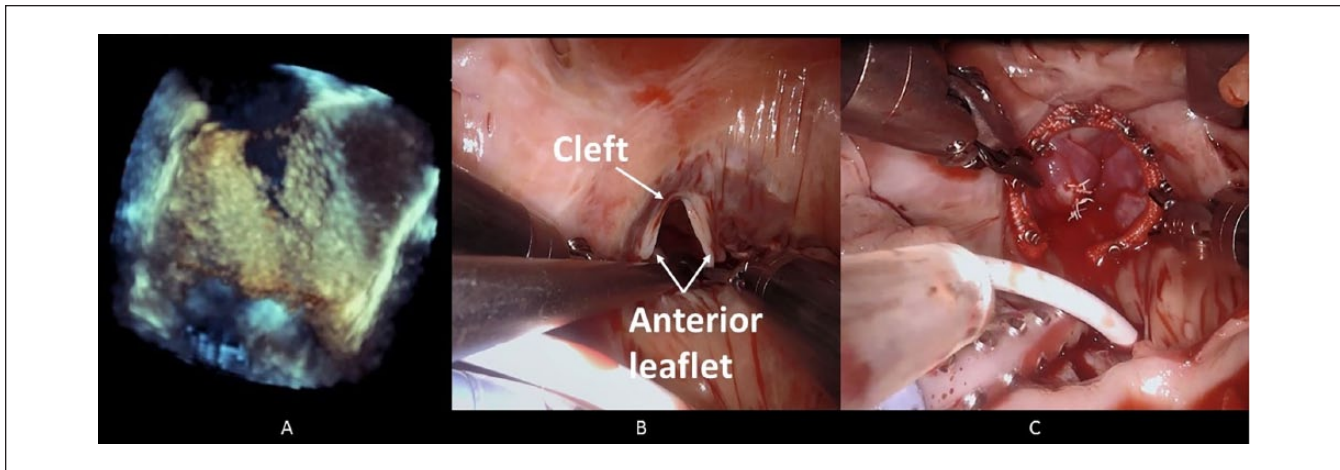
(A) Intraoperative transesophageal echocardiography shows a cleft in the anterior TV leaflet. (B and C) Intraoperative robotic images show a large cleft in the anterior TV leaflet before and after suture repair with tricuspid annuloplasty.
